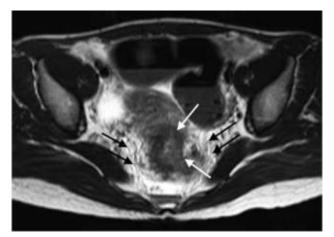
MRI axial sequence with T2 information. Mass is identified occupying the entire circumference of the rectum (white arrows), with alteration of the fat and involvement of the mesorectal fascia (black arrows) by tumor extension, associated with tumor ulceration, a finding related to colorectal tumor stage T3a.
